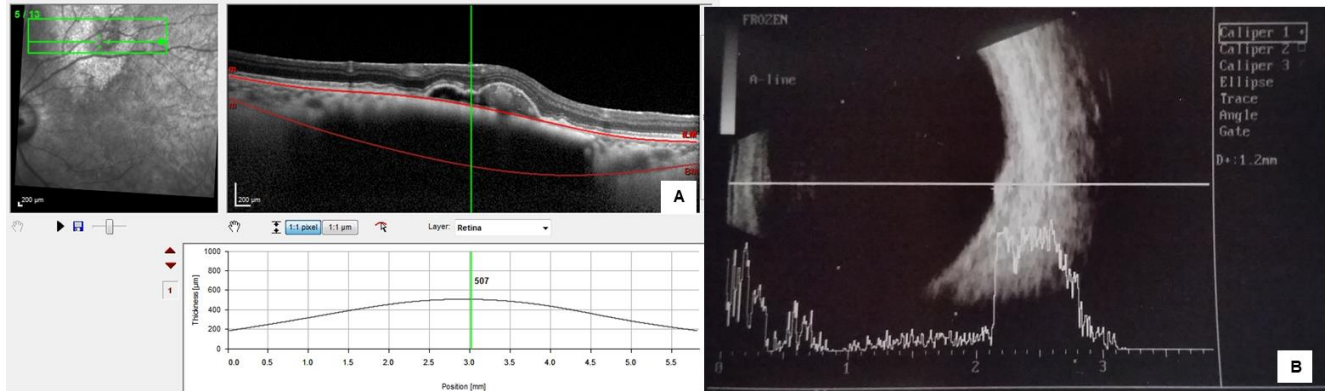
Choroidal nevus thickness measured by EDI-OCT and ultrasound. (A) With EDI-OCT the internal and external boundaries are identified (retinal and scleral thickness is not included in the measurement). (B) With US, in these small high reflective lesions is not possible to separate the different structures (retina, PED, choroid and sclera) and the thickness of the nevus is overestimated (507 μm / 1200 μm).
